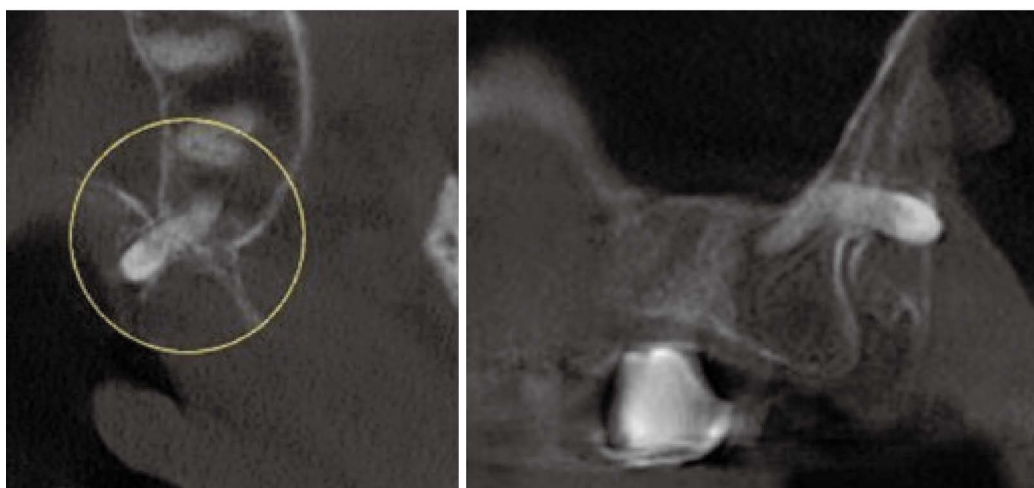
Axial and sagittal cone-beam computed tomographic images demonstrate an ectopic left maxillary third molar with a dilacerated root.
